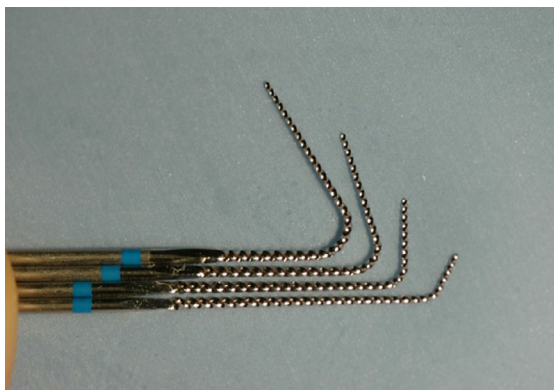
Ultrasonic files bent to various lengths and angles.
